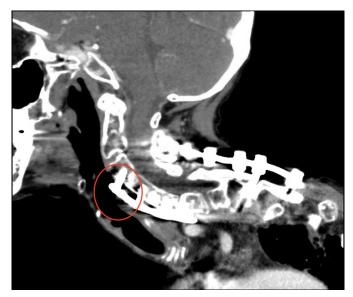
Sagittal view of the neck with contrast-enhanced computed tomography showing direct communication between the anterior cervical internal fusion plate and the hypopharyngeal airway.
